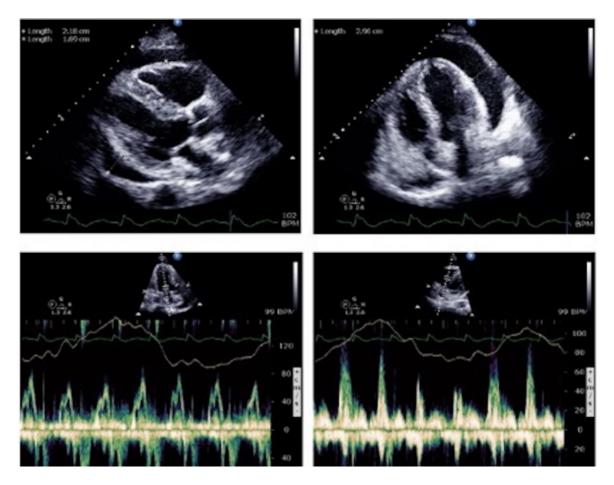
Echocardiogram prior to pericardiocentesis – Top panels: circumferential pericardial effusion measuring up to 2.96 cm. Bottom left panel: respiratory variation of diastolic mitral inflow. Bottom right panel: respiratory variation of diastolic tricuspid inflow.
